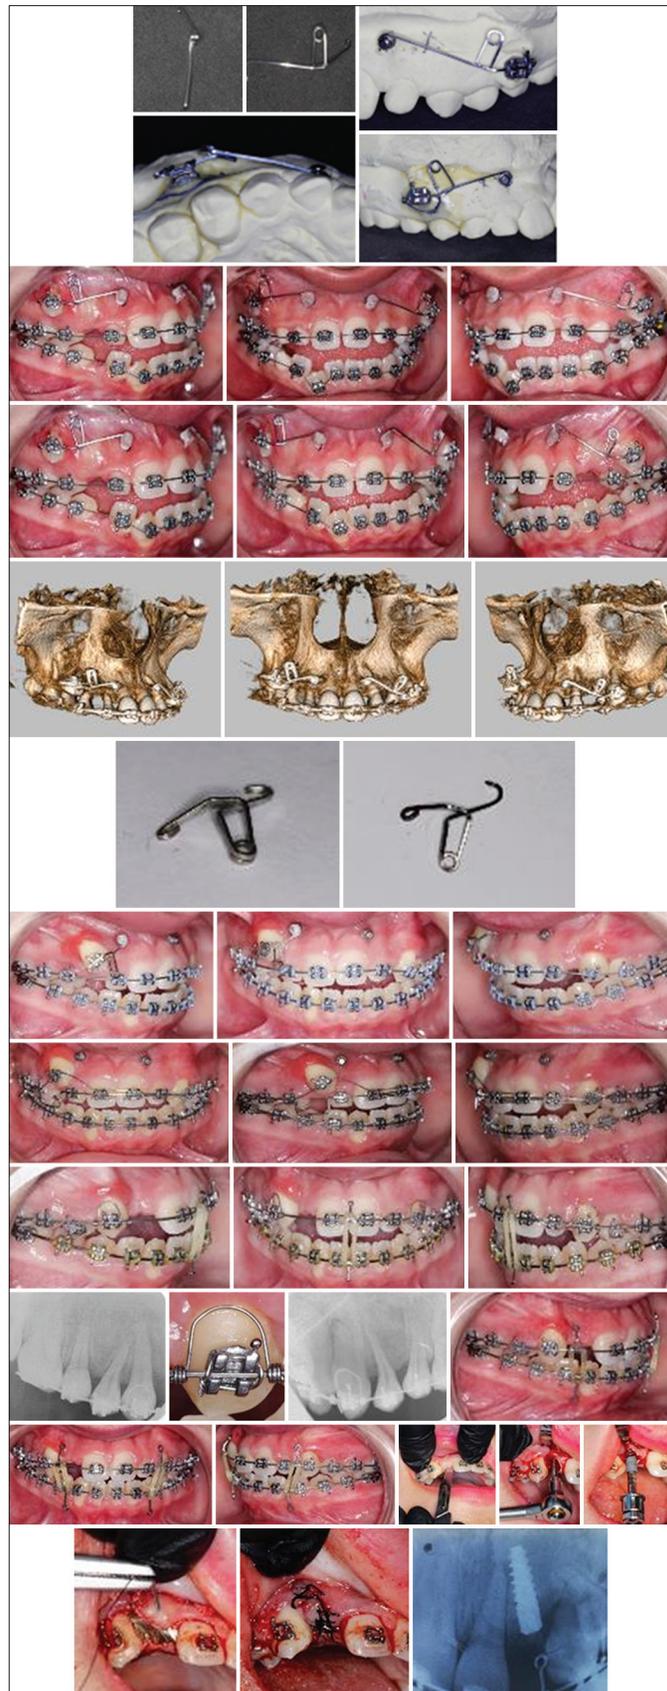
Show treatment mechanism and progressing including three-dimensional retraction loops construction on temporary anchorage devices and implant process confirmed with preapical and cone-beam computed tomography radiograph
